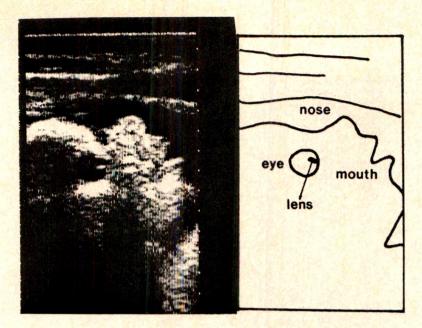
Optimal ultrasound image (fetal head including one orbit and mouth).
